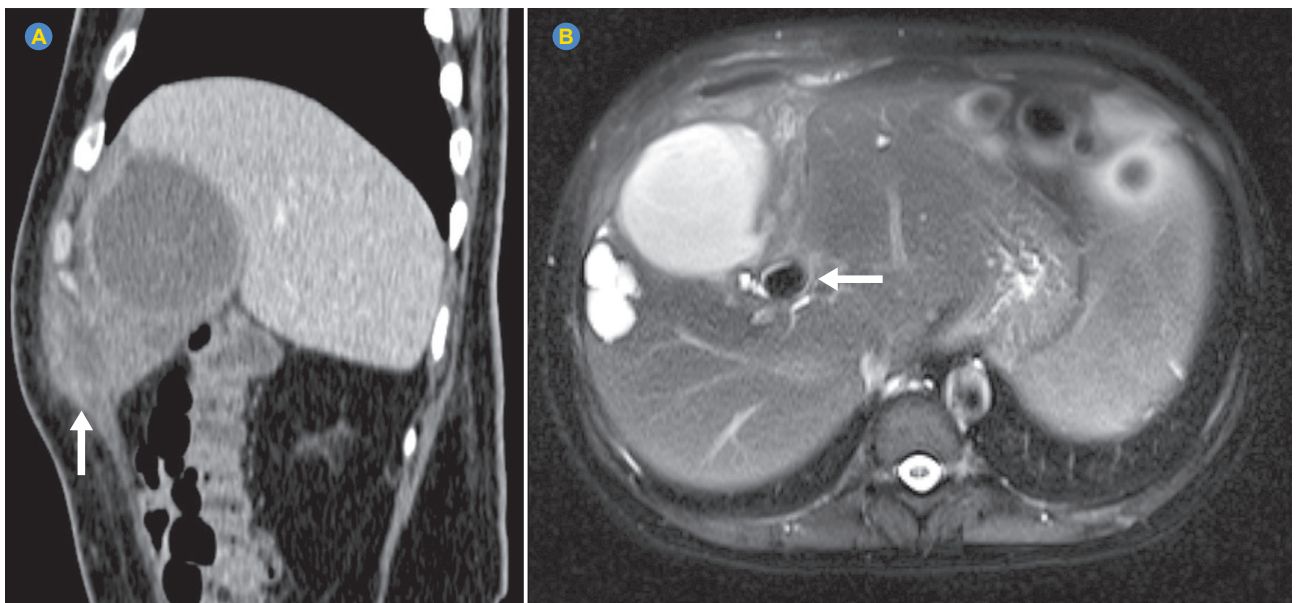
CT scan with contrast in the portal phase in the axial view (A) demonstrating abscess in the abdominal cavity at the location of the gallbladder invading the abdominal wall (white arrow). MRCP in the T2 FAT SAT sequence in the axial view (B) showing abscess in the gallbladder region which is in contact with the proximal portion of the cystic duct, in addition to obstructive lithiasis in the distal third of the duct cystic (white arrow), compatible with infected cholecystitis with fistulization to the abdominal wall.
